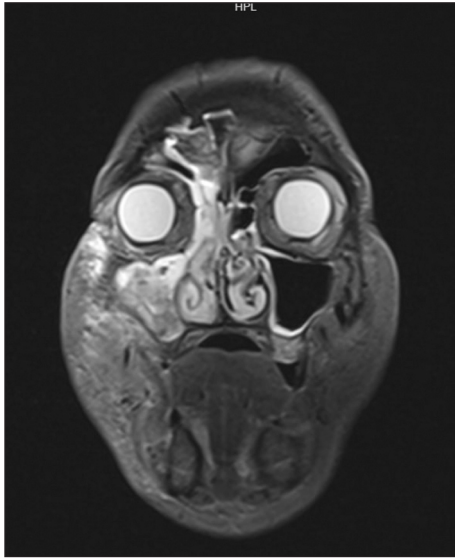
Magnetic resonance image before 1st surgery (sequence T2-tirm-cor).
